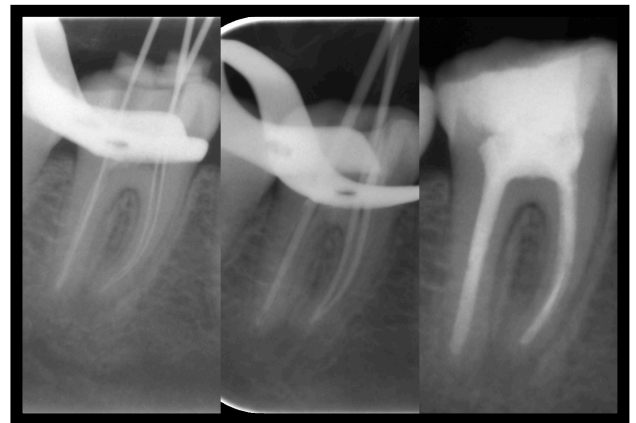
Treatment radiographs
